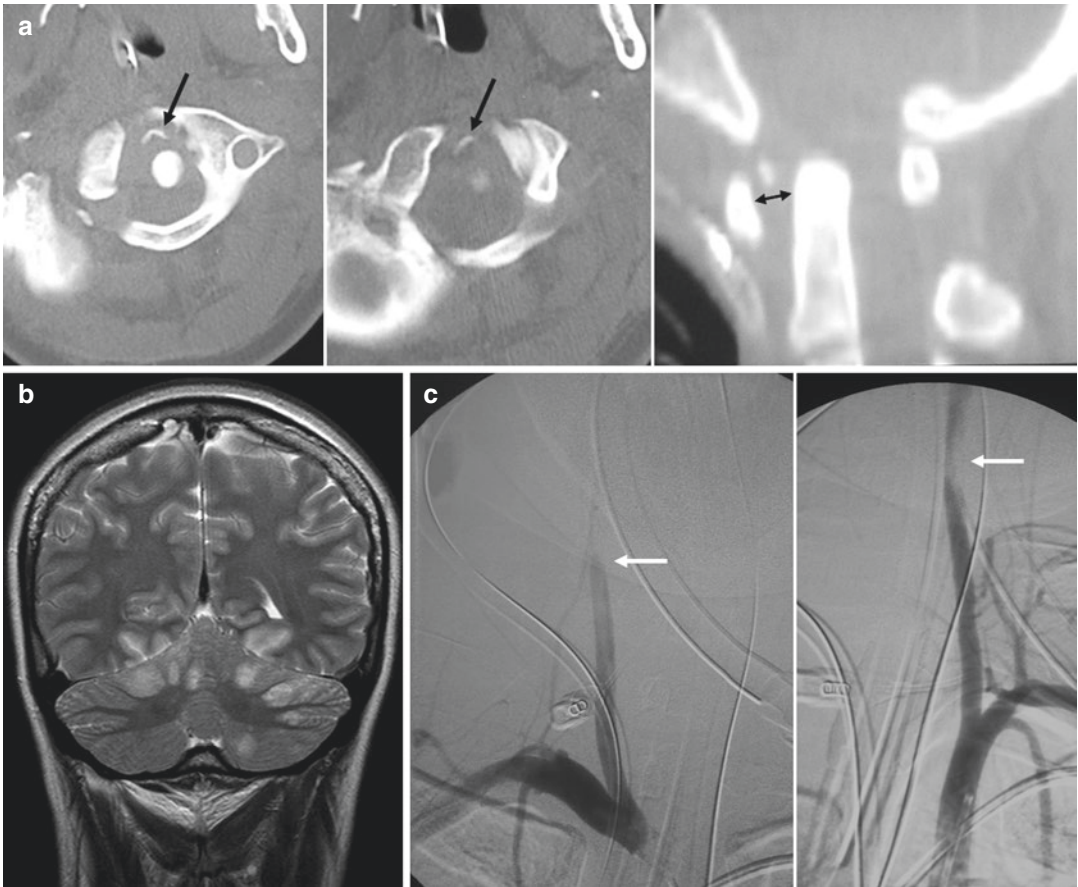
Fracture subluxation of the craniocervical junction complicated by bilateral vertebral artery dissection in pre-CTA era: source axial and 2D-reformatted sagittal CT images (a), T2-weighted coronal MR image of the head (b) and digital subtraction angiography anteroposterior view (c). At admission, CT showed type III left occipital condyle fracture from ipsilateral alar ligament
